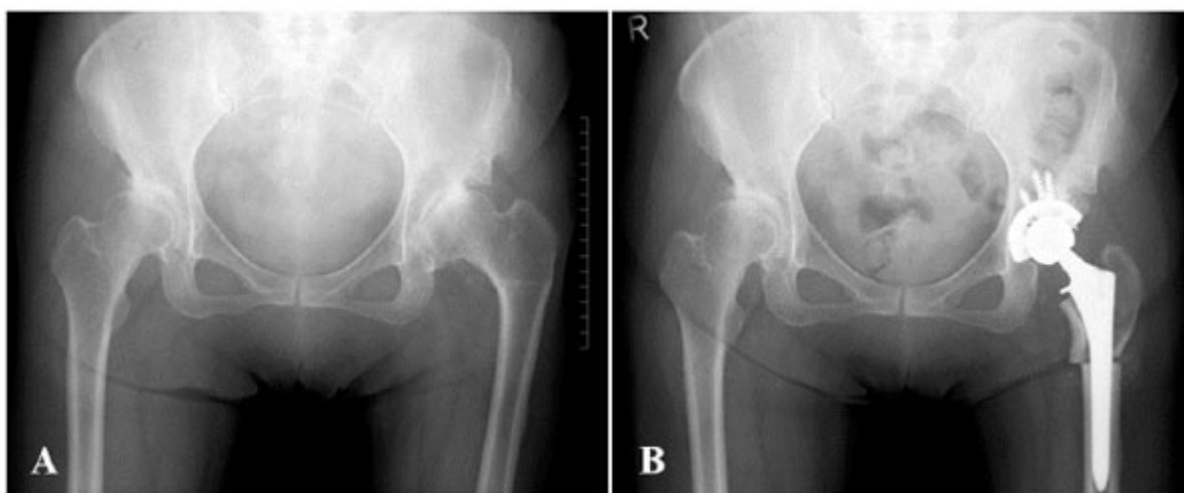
Pre- and postoperative radiographs of the left hip joint of a 60-year-old woman. (A) After failed left wedge varus osteotomy of the left femur. (B) Fifty-five months after total hip arthroplasty combined with subtrochanteric corrective femoral osteotomy.
